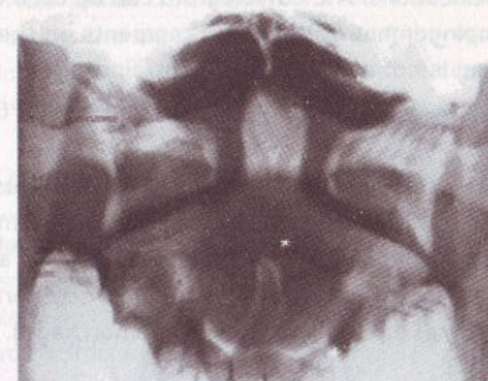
X-ray open mouth view showing odontoid process
